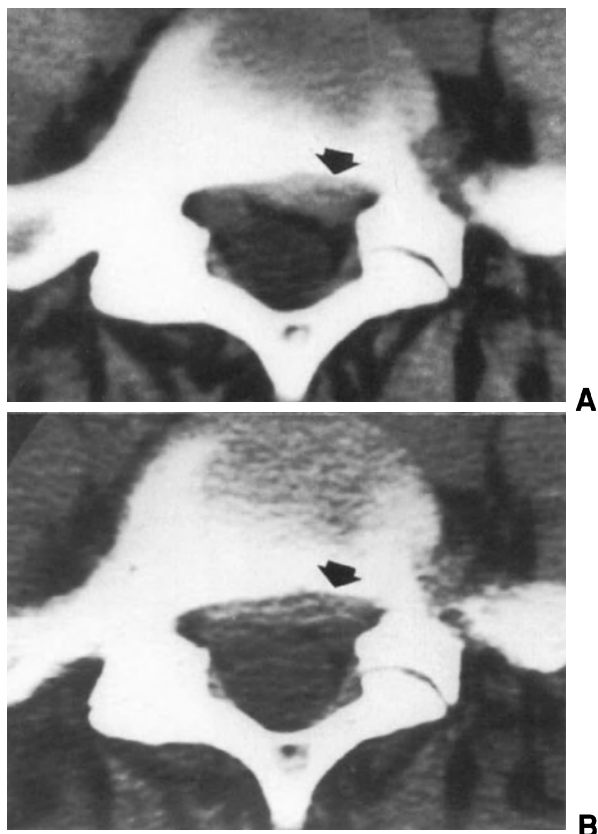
Axial CT scans at L5-S1 level, obtained before chemonucleolysis (A) and 4 months after the procedure (B). The extruded disc herniation present on the left side before nucleolysis is no longer visible after the procedure, however the disc shows diffuse annular bulging, probably resulting from decrease in height. Lumboradicular symptoms had completely disappeared.
